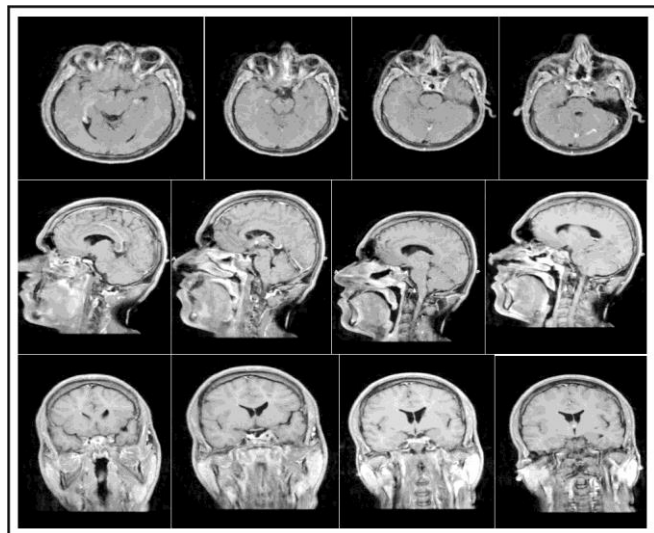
(B): Post-op MRI Brain (Images used with permission).
